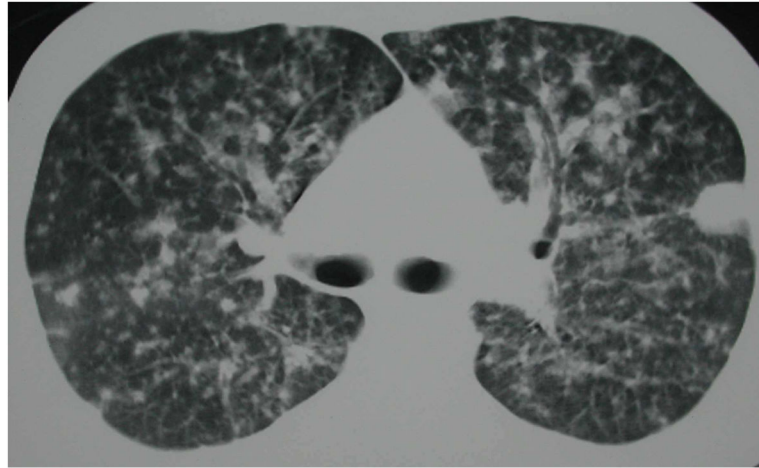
Axial HRCT of the chest of an HIV-infected patient with coccidioidomycosis. There are numerous nodules in a military pattern. Courtesy of Laurence Huang, MD; used with permission.
